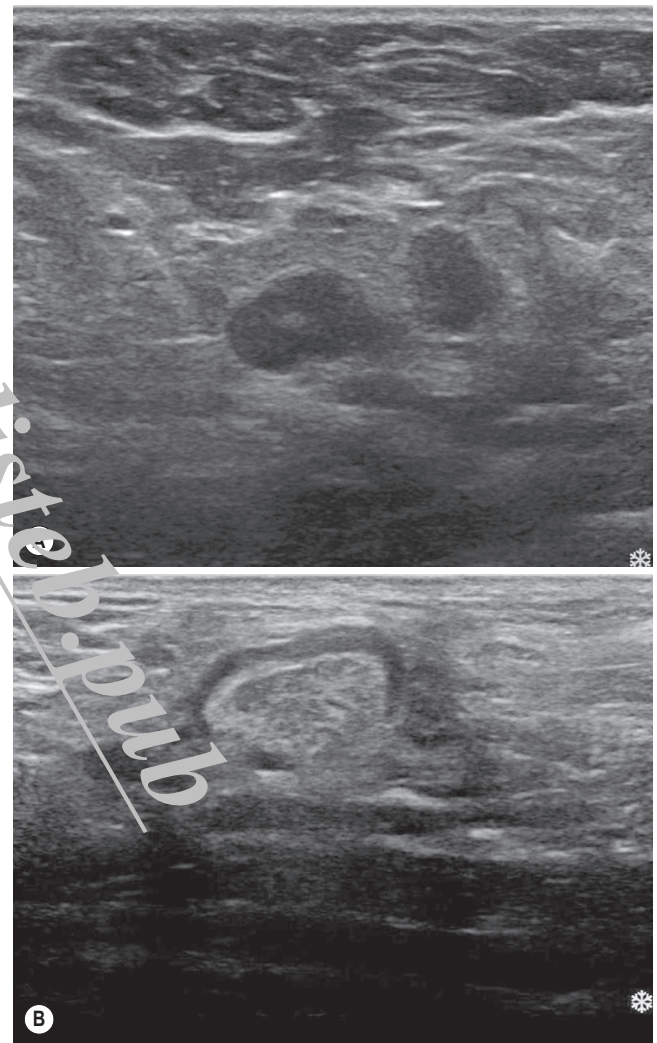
Axillary Lymph Nodes. Axillary lymph nodes can be assessed on the basis of shape and the morphology of the cortex. (A) Nodes are likely to contain tumour if their longitudinal-to-transverse diameter ratio is less than 2 (the node appears round rather than oval). Nodes are more likely to contain tumour if the cortex is thickened to more than 2 mm. (B) This node has a normal shape, but the cortex has a thickness of 3 mm. Ultrasound-guided biopsy showed a tumour containing lymph nodes in both cases.
